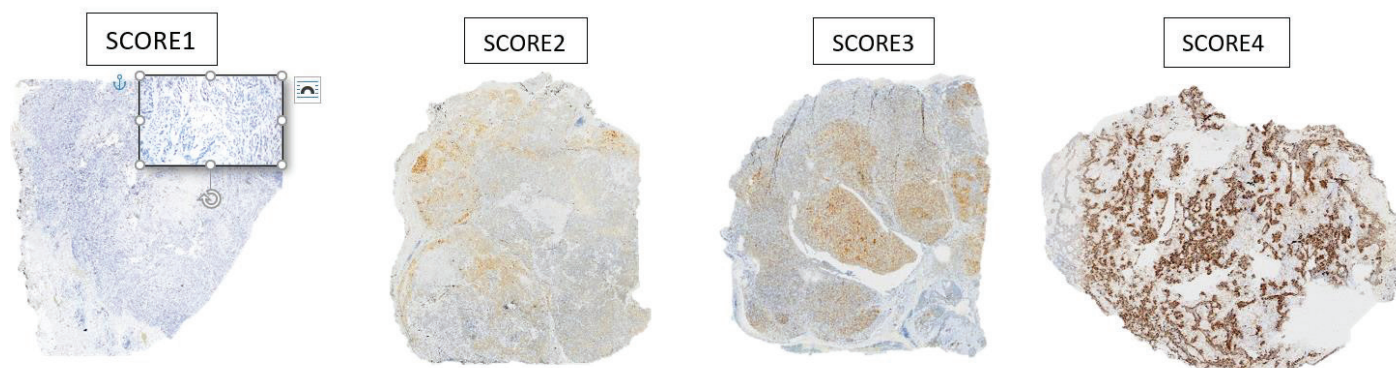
Tissue PSMA expression pattern as depicted
